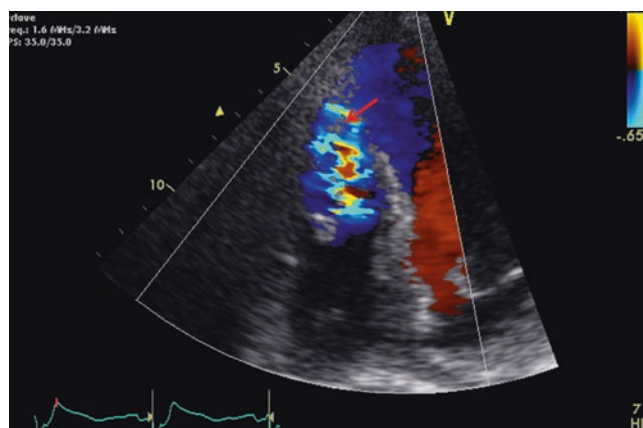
VSD with left-to-right shunting on color Doppler (red arrow). (Image courtesy of T. Metkus, M.D.)
